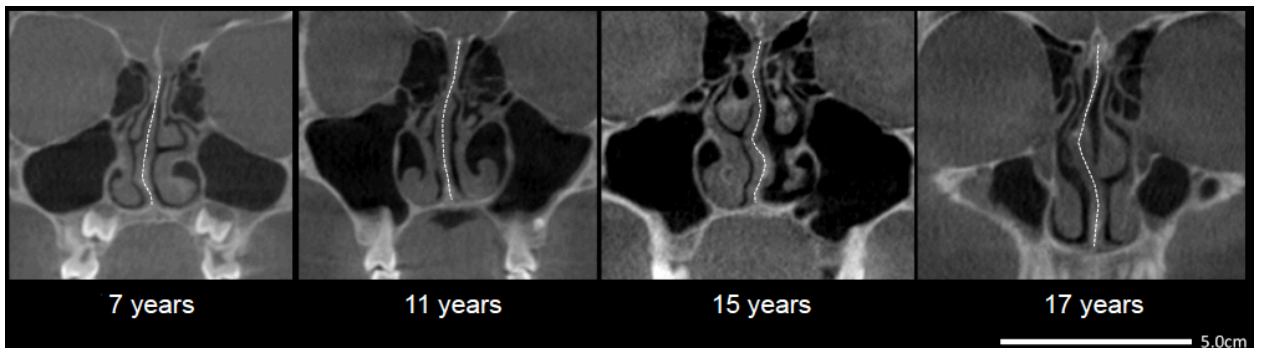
Examples of coronal cone beam computed tomography images of subjects with nasal septal deviation. Nasal septal deviation (white dashed line) is present throughout all ages in the sample.
